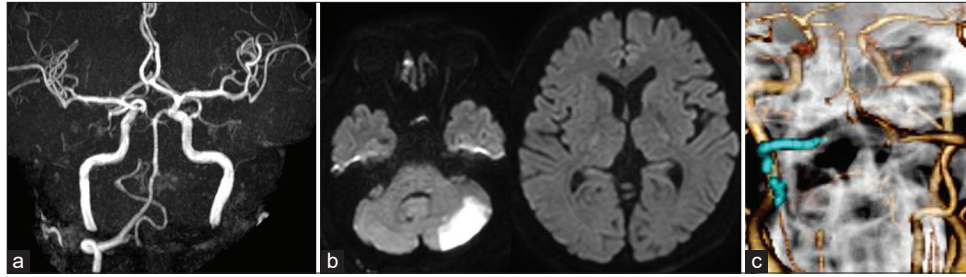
Postoperative imaging findings. Magnetic resonance angiography showing occlusion of the left vertebral artery (a). Diffusion-weighted magnetic resonance imaging showing no new cerebral infarction (b). Computed tomography angiography showing occlusion of the left vertebral artery (c).
